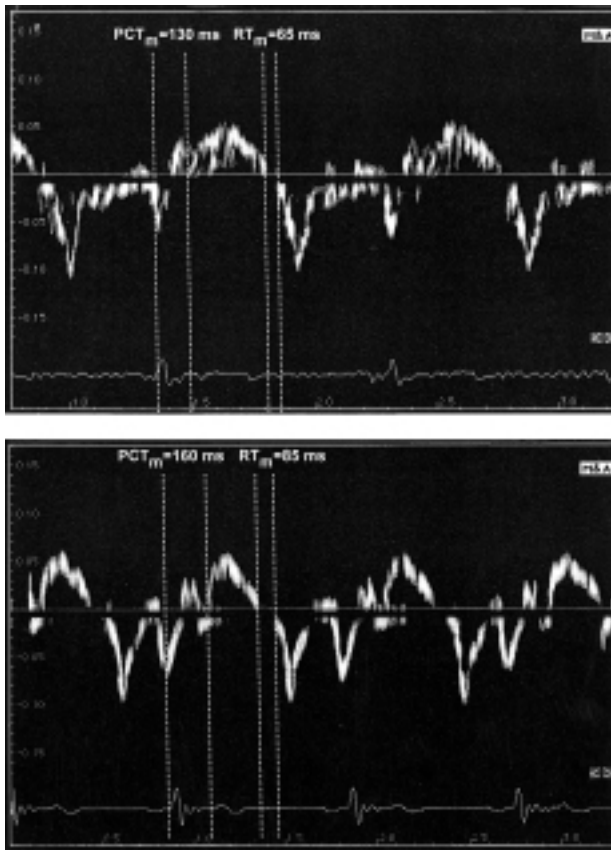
Pulsed tissue Doppler pattern of the posterior septum in a healthy woman (upper panel) and in a woman with overt hypothyroidism (lower panel). The E_m/A_m ratio is > 1 in both cases, but the myocardial pre-contraction time (PCT_m) and relaxation time (RT_m) are longer in the patient with overt hypothyroidism.
